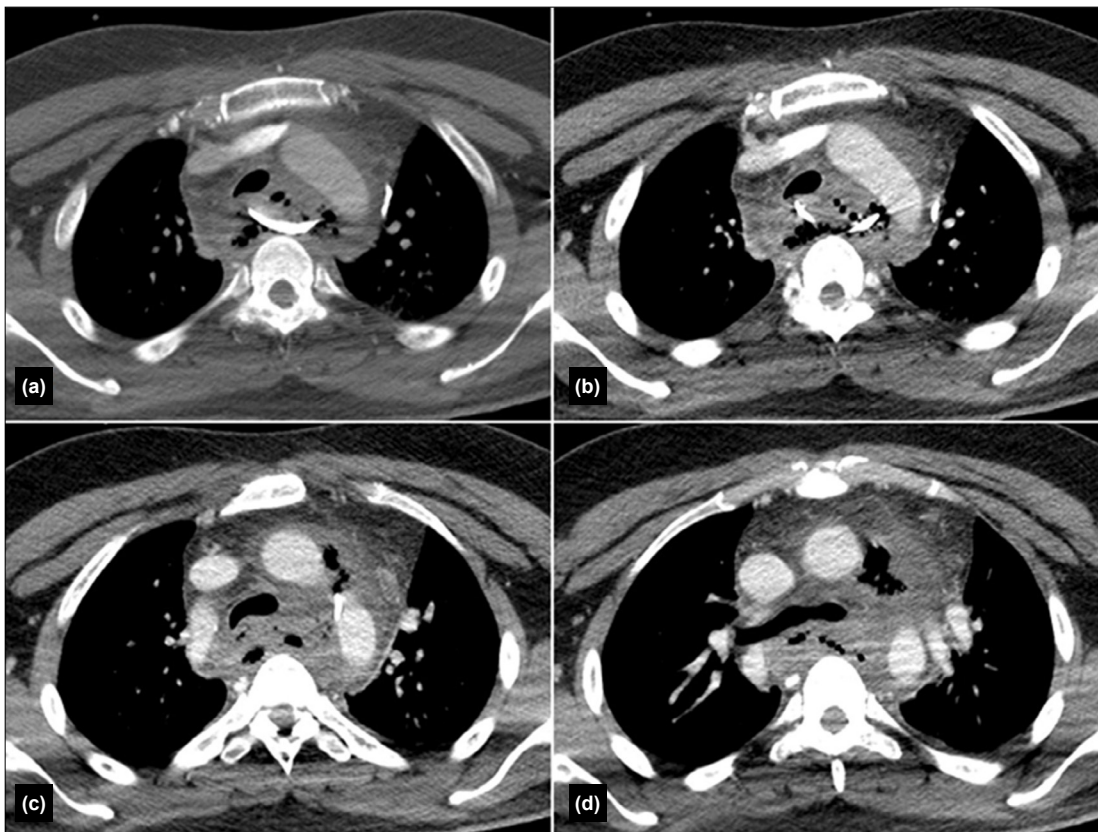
Contrast-enhanced chest computed tomography (CT) showing a large semicircular metallic foreign body perforating the esophageal wall and penetrating the posterior wall of the thoracic aorta, with surrounding mediastinal fluid accumulation and gas formation consistent with abscess formation.
